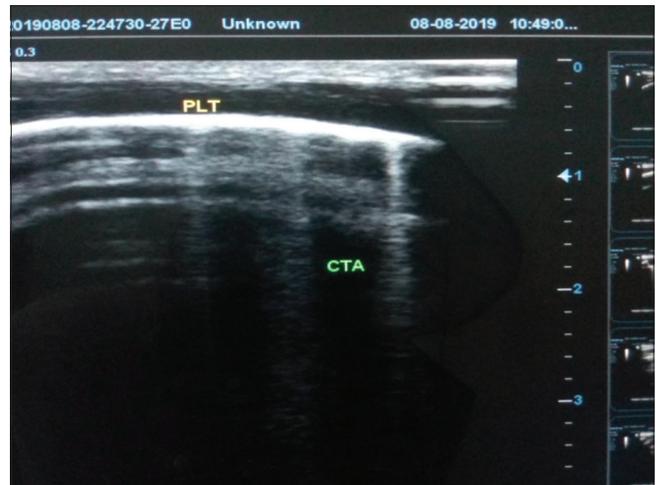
Transverse lung ultrasound scan using high frequency transducer showing comet tail artefacts (B-lines)
